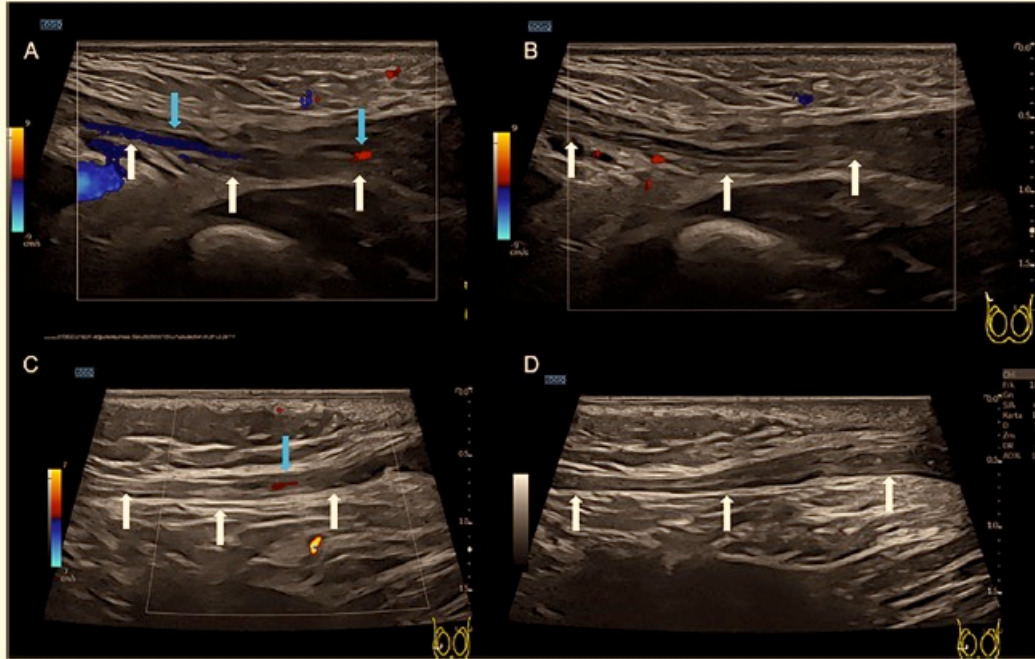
Spermatic cord was identified with normal appearance when ultrasound was performed at the age of two weeks (A and B) and at the age of three months (C and D). The white arrows indicate the spermatic cord in the inguinal canal. The blue arrow indicates arterial blood flow that can be seen in the spermatic cord in image A and C.
